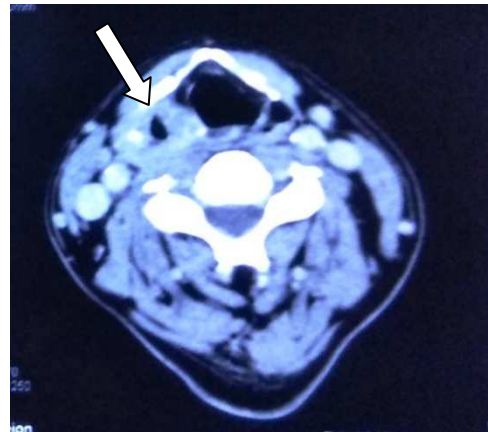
Axial plane contrast enhanced computed tomography of neck shows moderately enhancing soft tissue density thickening of right aryepiglottic fold and pyriform sinus
